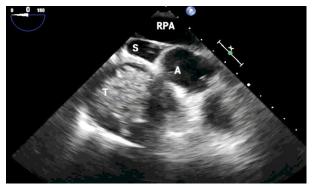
Transesophageal echocardiography upper esophageal view showing the tumor adjacent to superior vena cava (S), aorta (A) and right atrium. Abbreviations-S= superior vena cava, A= aorta, T= teratoma and RPA= right pulmonary artery
